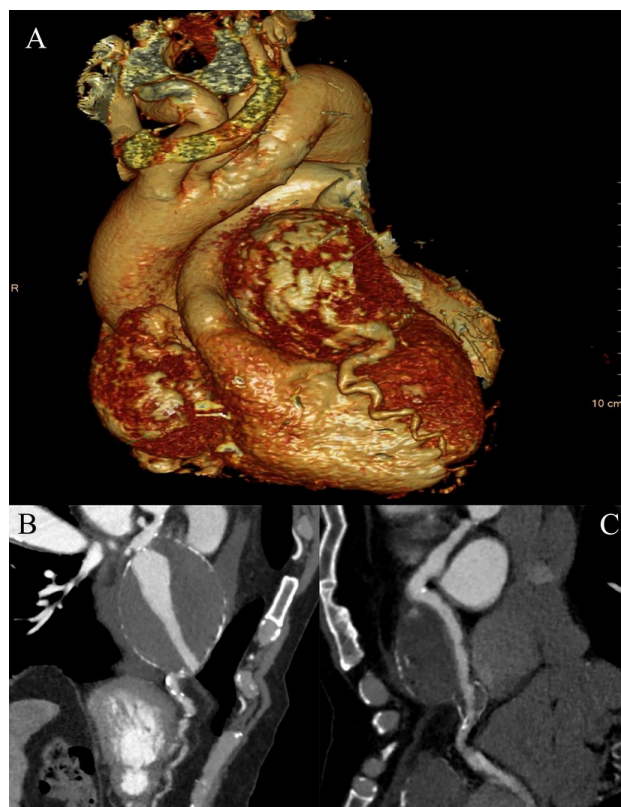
Routine multidetector computed tomography (MDCT) angiography revealed two giant coronary artery aneurysms (GCAAs). (A) Overview image demonstrating the presence of both aneurysms. (B) Giant aneurysm of the left anterior descending (LAD) artery measuring 75 mm in maximum diameter. (C) Giant aneurysm of the right coronary artery (RCA) measuring 48 mm in maximum diameter.
